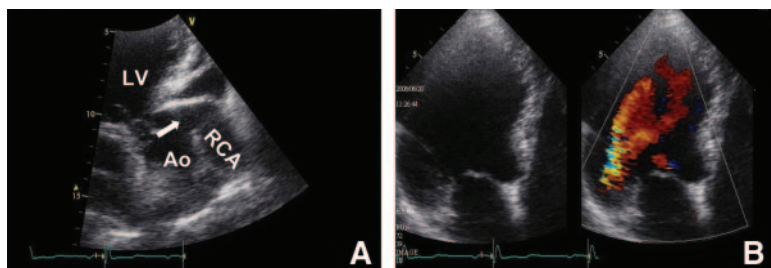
Two-dimensional transthoracic echocardiography in the 3-chamber view (A) revealed dilation of the proximal RCA (indicated by arrow). Color Doppler imaging in the apical 4-chamber view (B) demonstrated abnormal turbulent flow originating just beneath the lateral aspect of the mitral annulus.
